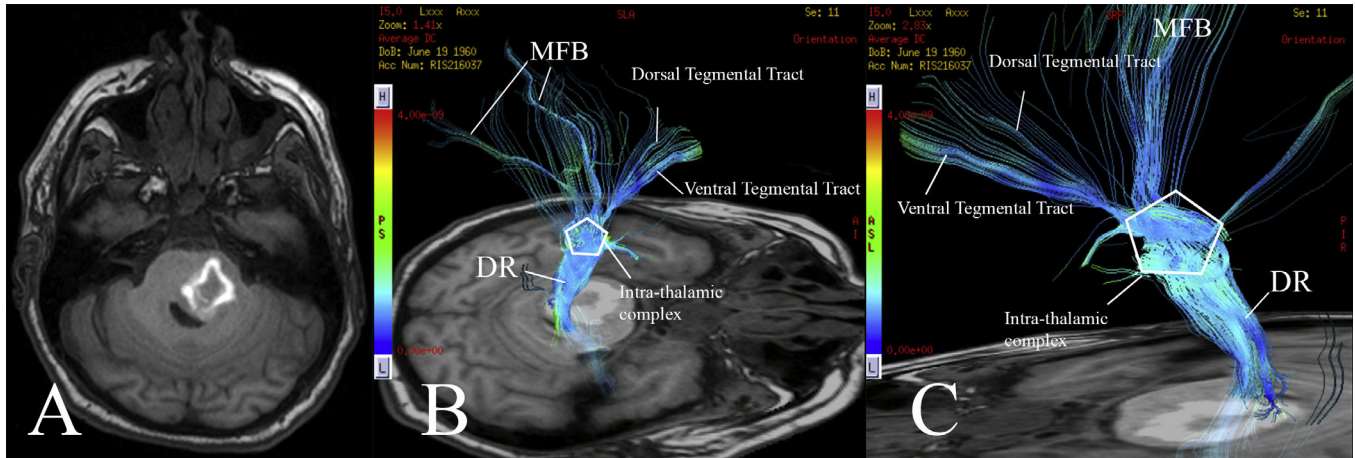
Fusion of an axial T1 non-enhanced magnetic resonance imaging with tractography tracing of the ascending reticular activating system. (A) An axial non-enhanced T1 showing a left pontine cavernous malformation with hemorrhage. Left (B) and right (C) superior-lateral views of the fusion of the tractography and the T1 demonstrating the hemorrhage displacing posteriorly the dorsal raphè fiber tracts. The ventral and dorsal tegmental tracts remain intact, as well as the Middle Forebrain Bundle tracts bilaterally. DR = dorsal raphè, MFB = Middle Forebrain Bundle.
